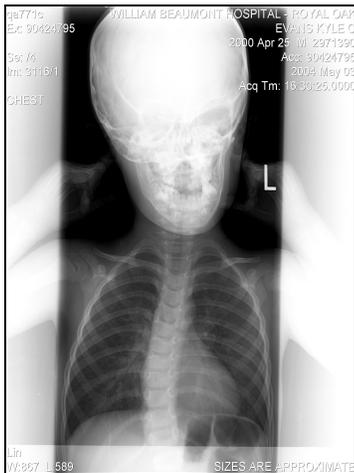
Standing chest PA x-ray with arms up.
